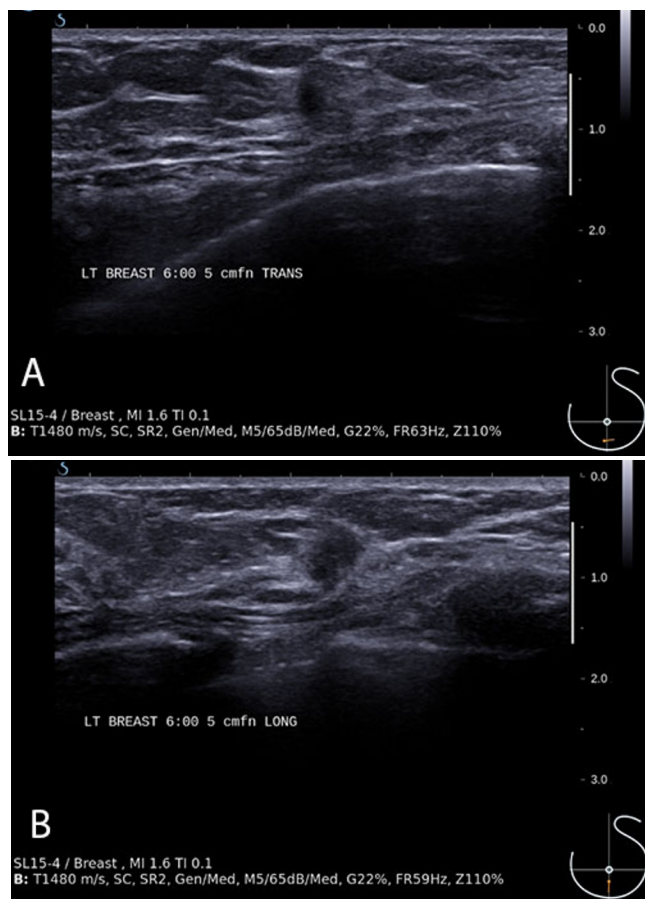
65-year-old female with granulomatous inflammation and invasive ductal breast carcinoma. Before ultrasound-guided needle localization for lumpectomy, targeted left-breast ultrasound focusing on 6 o'clock was performed (A: transverse view; B: longitudinal view). It demonstrated an irregular hypoechoic mass, taller than wide, with ill-defined margins at 6 o'clock, 5 cm from the nipple, measuring 8x4x6 mm. This finding was consistent with biopsy-proven invasive ductal carcinoma done in an outside facility.
